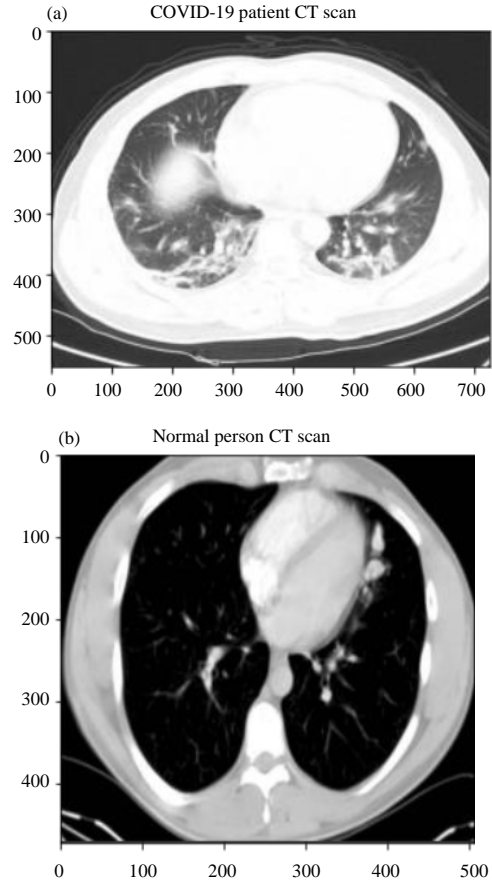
(a, b): Sample original images in dataset, (a) COVID CT and (b) Normal CT
